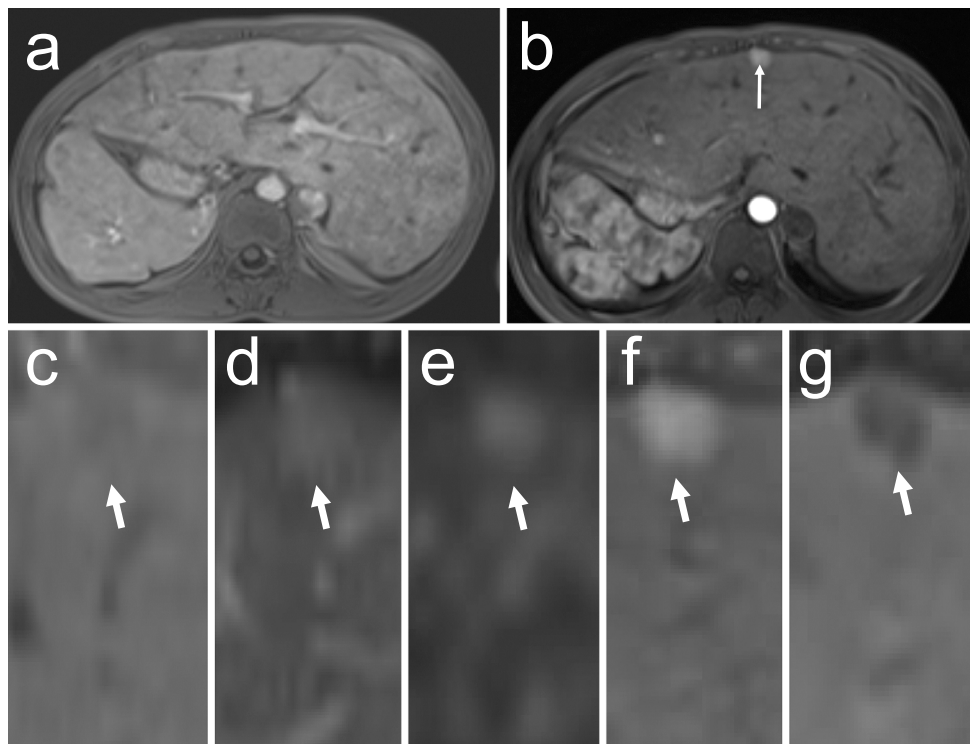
There was radiographic evidence of liver cirrhosis with portal hypertension, including a nodular surface, a coarse texture, ascites, and splenomegaly on MRI (a, b). Gd-EOB-DTPA MRI showed a 15 mm S4 mass with a moderately low intensity in T1-WI (c), moderately high intensity in T2-WI (d), moderately high intensity in diffusion (e), homogeneous arterial enhancement (b, f), and complete washout in the hepatobiliary phase (g).
